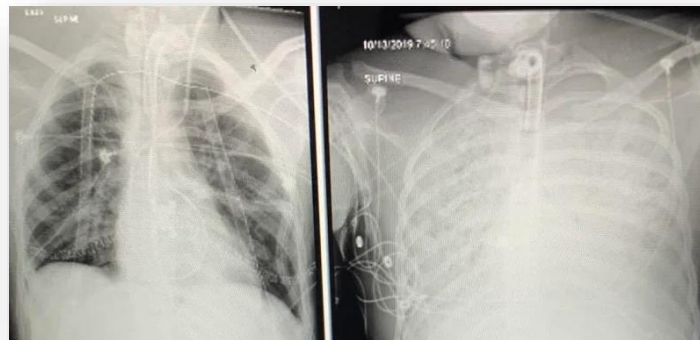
Ament's lung x-rays, courtesy of the Ament family
